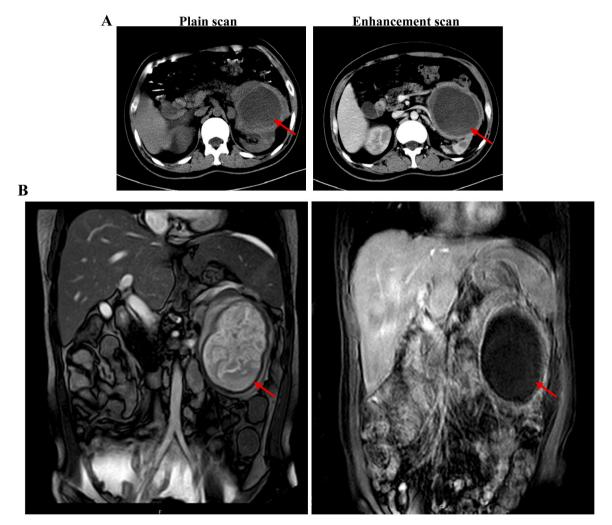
Preoperative abdominal computed tomography and magnetic resonance imaging. (A) Computed tomography showed a large space-occupying lesion in the left kidney. The largest cystic lesion was approximately 6.6×5.6 cm in size (red arrow). (B) A magnetic resonance imaging scan showed multiple space-occupying lesions in the left kidney. The cystic lesion (red arrows) in the kidney showed long T1 and long T2 signals, and the cystic wall was slightly enhanced on an enhanced scan.
